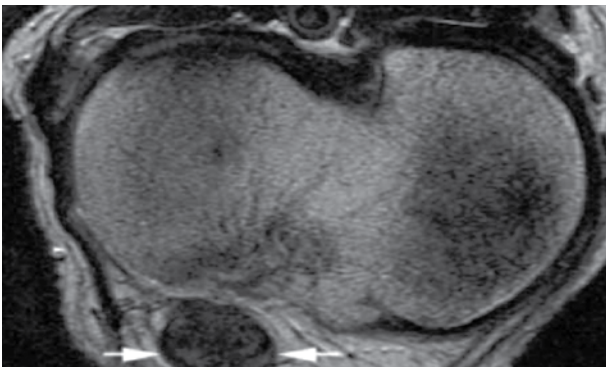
A negative field recovery CT image of the pentetreotide scan demonstrating a mass behind the right knee (see arrows)
